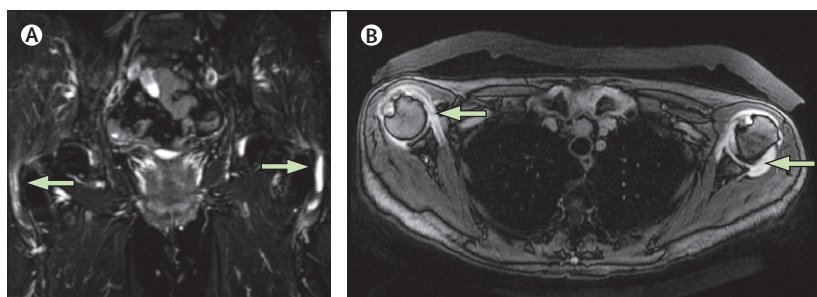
MRI in a patient with polymyalgia rheumatica
